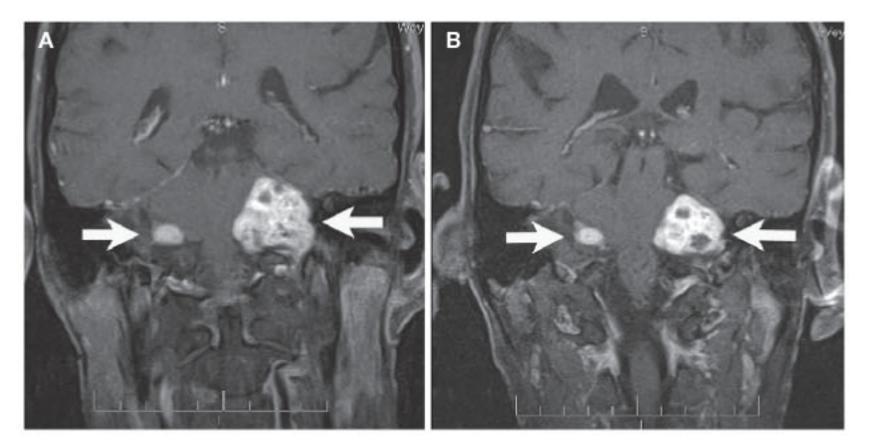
Cranial MRI scans of the patient before and after treatment with erlotinib. (A) A post-contrast T1-weighted coronal MRI scan of the patient before erlotinib therapy. The arrows indicate bilateral vestibular schwannomas characteristic of neurofibromatosis type 2. (B) A repeat MRI scan after 11 months of erlotinib therapy showing the decreased size of the left vestibular schwannoma.
